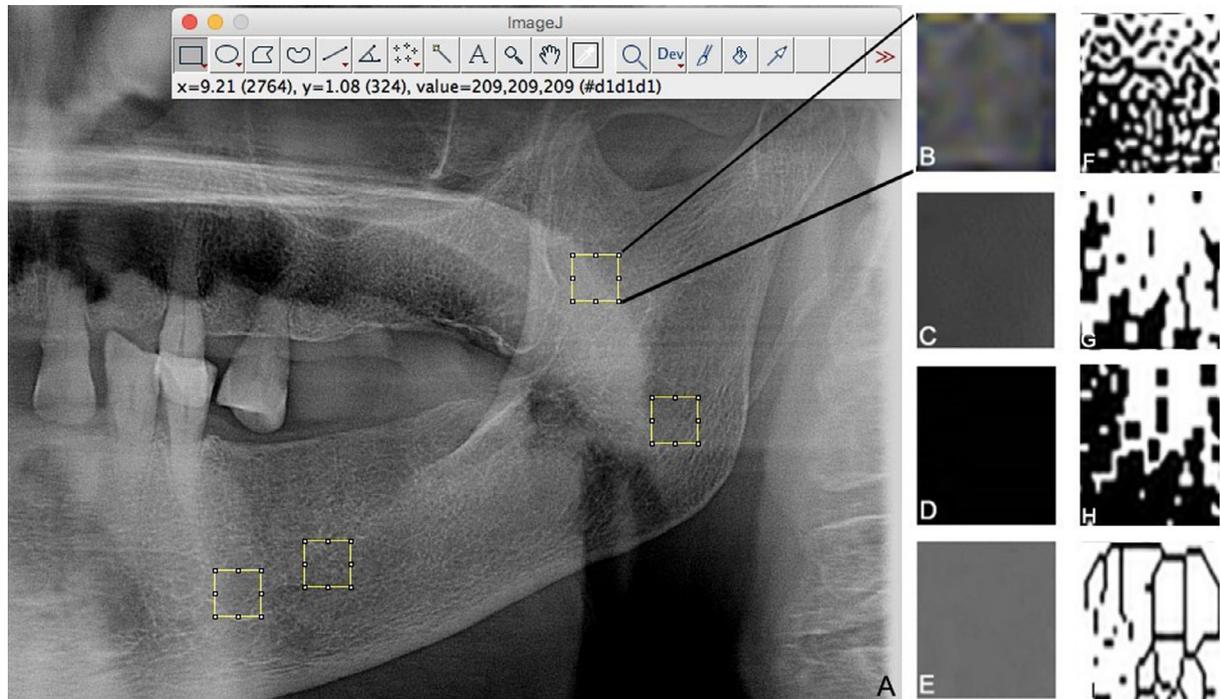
(A) Panoramic radiograph with 4 selected regions of interests. (B) Original image. (C) Gaussian blurred image. (D) Subtraction image. (E) Added 128 image. (F) Binary image. (G) After “erode.” (H) After “dilate.” (I) Skeletonization.
